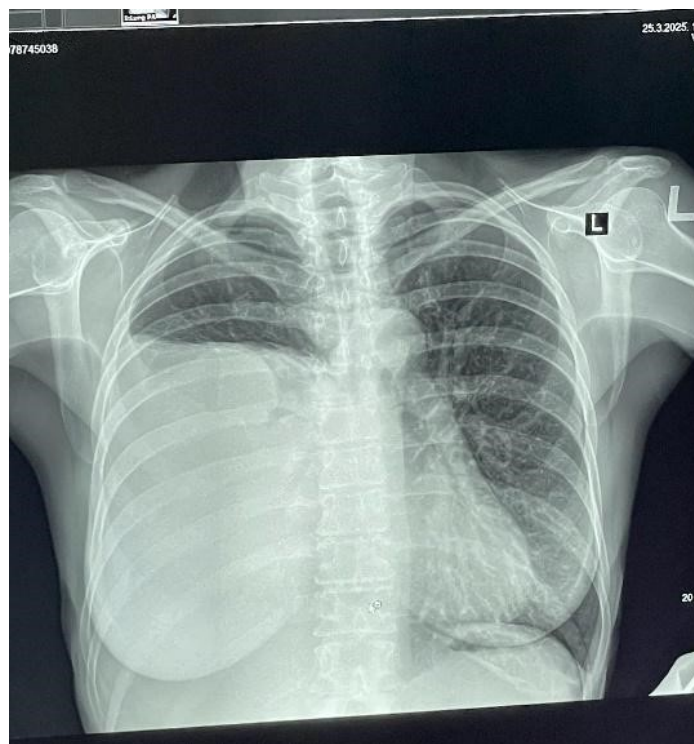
X-ray image of the heart and lungs of a woman at 30 weeks of gestation showing massive right pleural effusion extending to the anterior margin of the second rib, with a well-defined oval tumor shadow in the right hemithorax and involving almost the entire right lung parenchyma.
